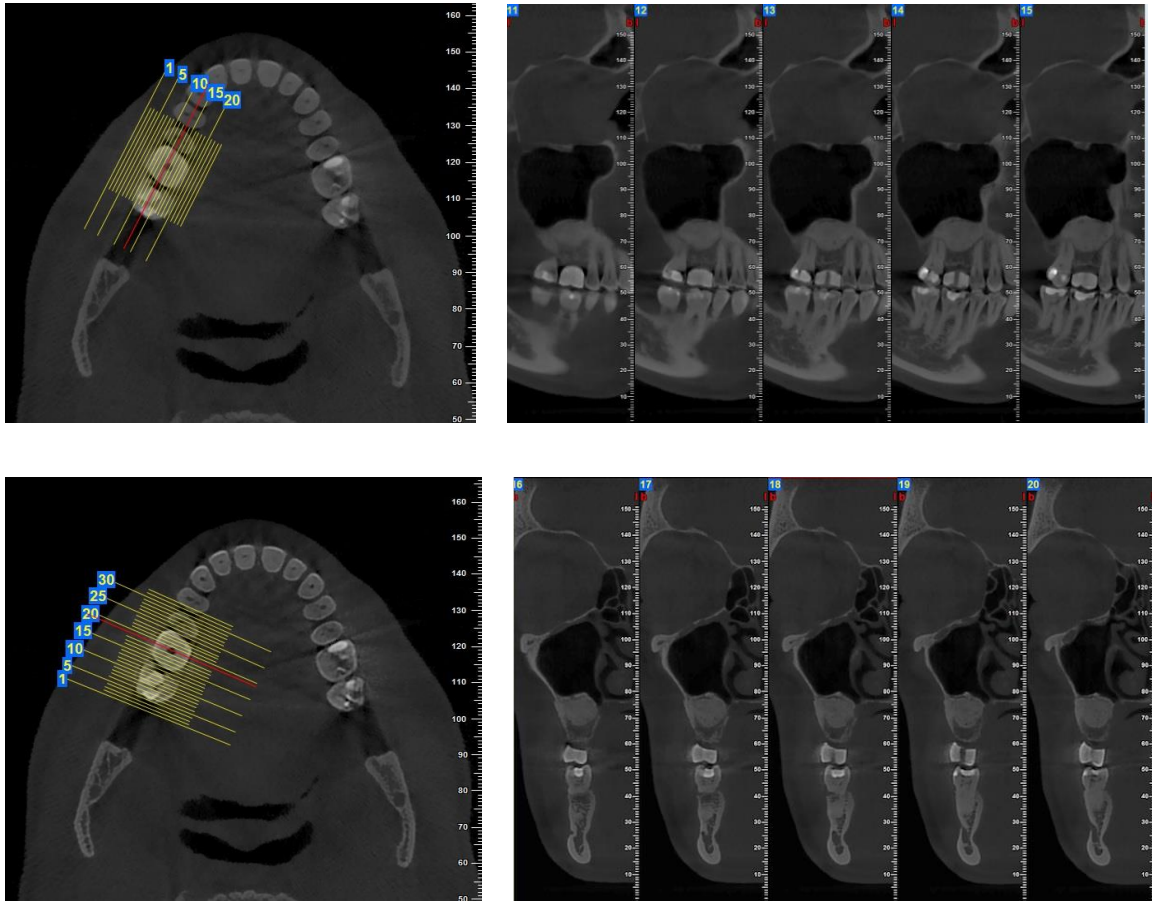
Post-operative CBCT image
